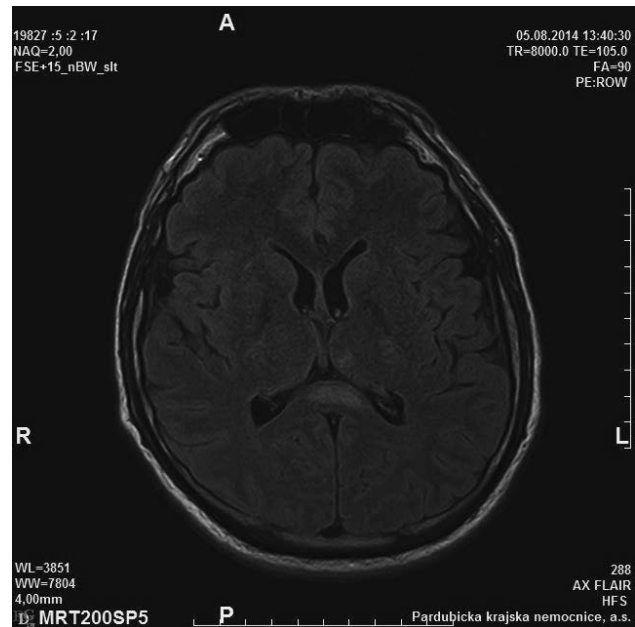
MRI of the brain, axial FLAIR – hyperintense lesions of the splenium of the corpus callosum and the left thalamus.
